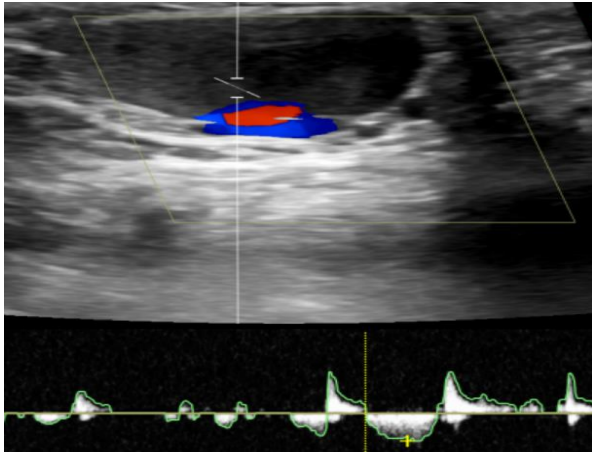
Spectral Doppler of the pseudoaneurysm shows a typical to-and-fro waveform.
